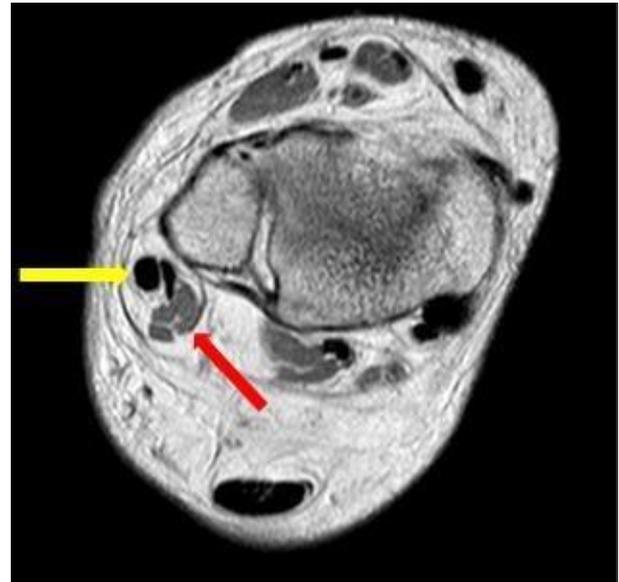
axial cut MRI image of right ankle. Red arrow showing PQ and yellow arrow showing the peroneus brevis and longus tendons.
